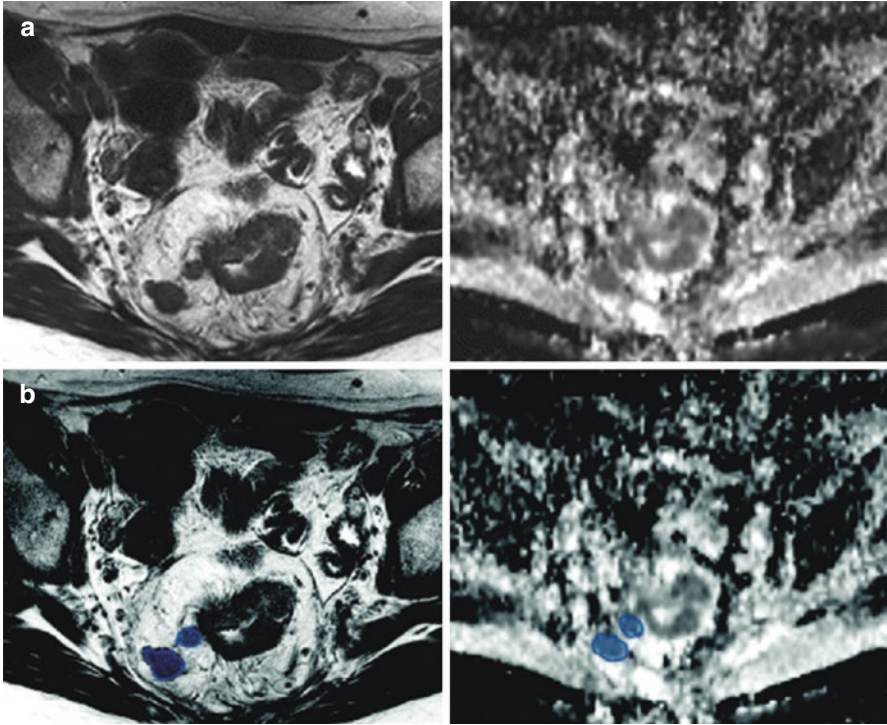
(a, b) Axial oblique T2-weighted images in a patient with rectal cancer shows metastatic inferior mesenteric lymph node (blue)
